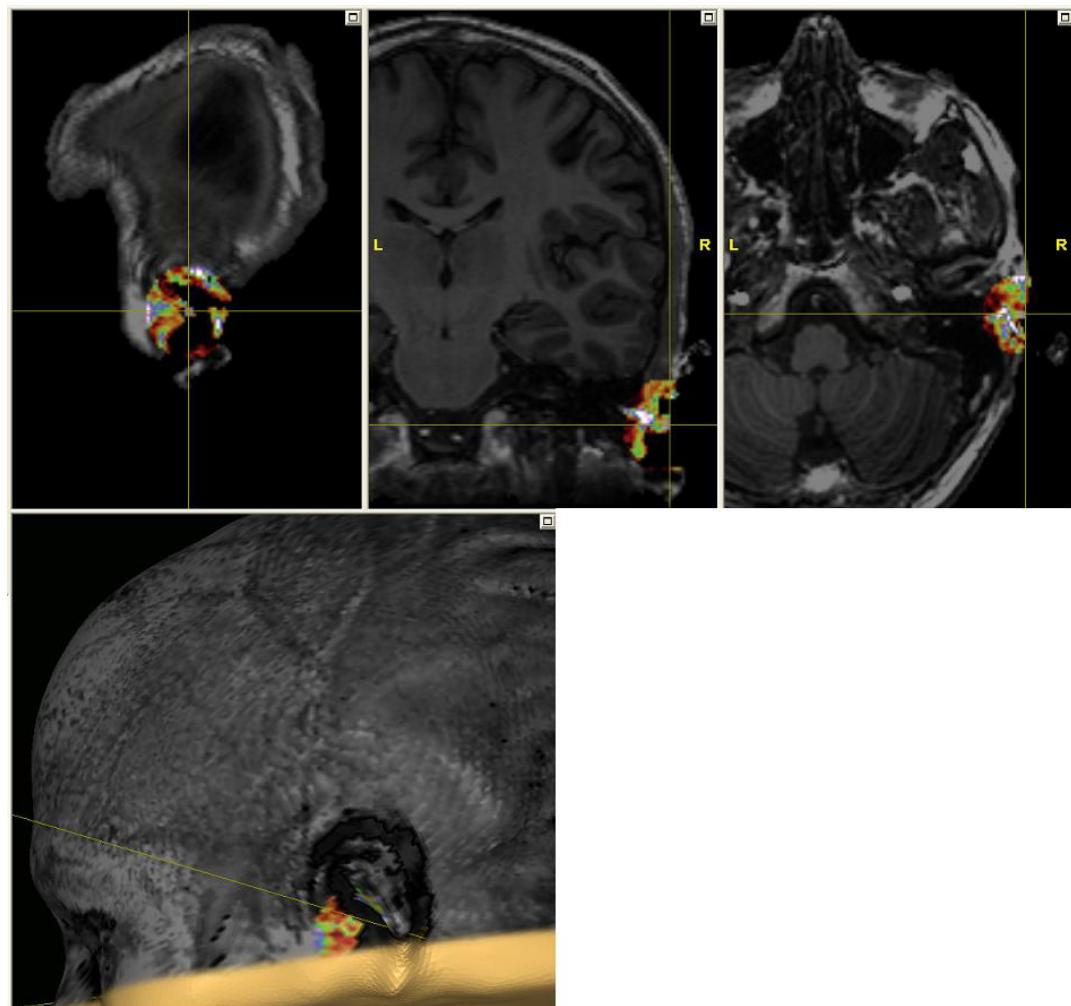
Rainbow colormap: Location of the right ear landmark in MR images and 3D head
